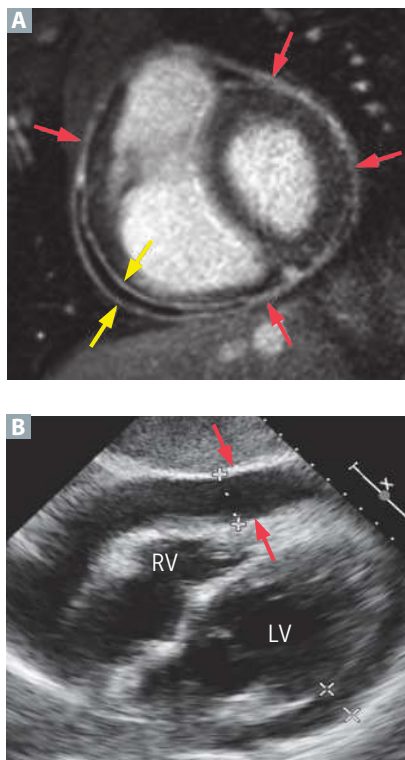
Radiographic findings in pericarditis. (A) MRI demonstrates an effusion (yellow arrows) within the pericardial sac (red arrows). Pericardial effusion is diagnosed when the pericardial space is >3 to 4 mm in diameter (a normal pericardial space has 30–50 mL of fluid, and this space is ≤ 2 mm in diameter). (B) Echocardiography showing pericardial effusion (red arrows). (Image A adapted with permission from Bogaert J, Francone M. Cardiovascular magnetic resonance in pericardial diseases. *J Cardiovasc Magn Reson.* 2009;11[1]:14. doi:10.1186/1532-429X-11-14. Image B adapted with permission from Yousuf T, Kramer J, Kopiec A, et al. A rare case of cardiac tamponade induced by chronic rheumatoid arthritis. *J Clin Med Res.* 2015;7[9]:720–723. doi:10.14740/jocmr2226w.)
